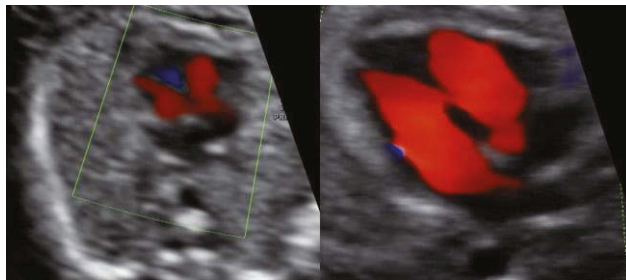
Double inlet left ventricle (DILV) seen in color Doppler during first trimester screening (left) and mid-trimester screening (right).
